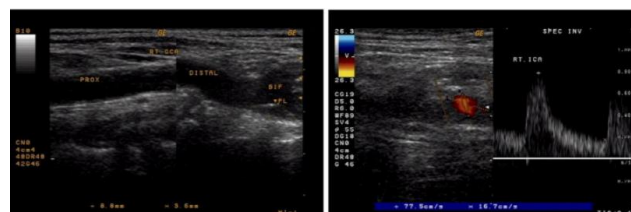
B mode and colour Doppler imaging showing hypochoic plaque at carotid bifurcation with luminal narrowing of <50% (case no.1)
